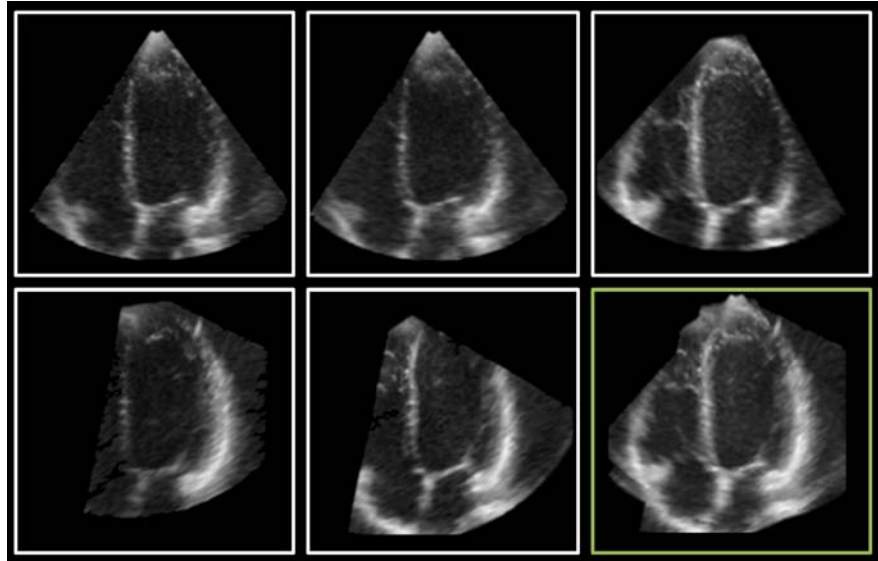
Fusion example of five 3D echocardiography images. A representative 2D slice from each volume is shown, followed by the same slice in the fused volume, which is shown in the lower-right corner. (reproduced from [Rajpoot 2009])
